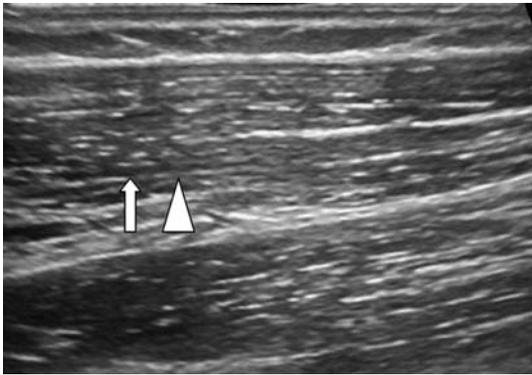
Longitudinal ultrasound image of the biceps muscle demonstrating multiple, linear, hypoechoic cylindrical structures: the fasciculi. A muscle fasciculus (arrow) is shown separated by the thin hyperechoic intervening connective tissue, the perimysium (arrowhead).
